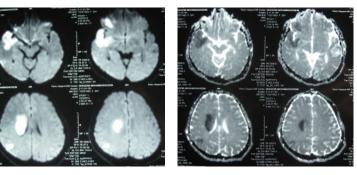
Brain MRI 24 hours after event shows ischemic lesion in right MCA territory
